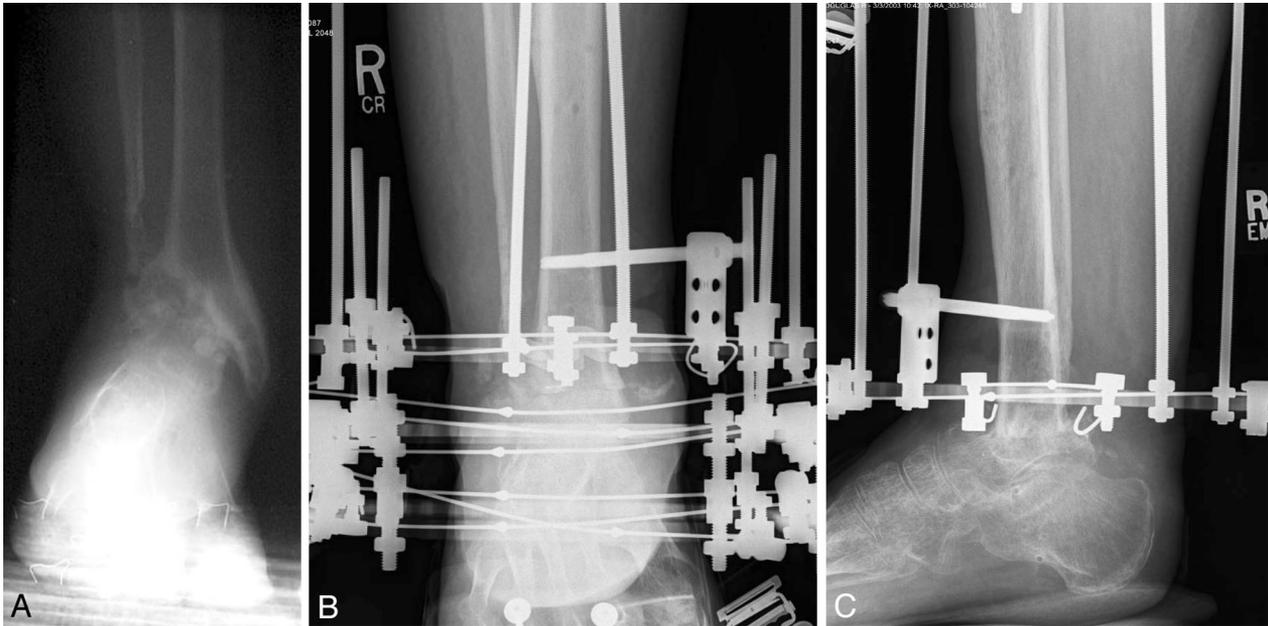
Associated infection of bone/active nondraining infections. (A) A presenting radiograph of a 48-year-old man referred in following multiple failed attempts at an ankle fusion using a variety of internal fixation techniques. The patient is HIV-positive and has had a history of recurrent episodes of fever and cellulitis to the ankle region, including several recent episodes. (B) The patient was treated with debridement and bony resection, acute shortening, and compression at the junction of the tibia and talus. This anteroposterior radiograph was taken during slow continued gradual compression following acute compression in the Ilizarov external fixator. (C) This lateral radiograph following removal of all foot fixation shows solid fusion of the ankle. The Ilizarov external fixator remains in place as the patient is now undergoing limb lengthening through a proximal tibial corticotomy.
